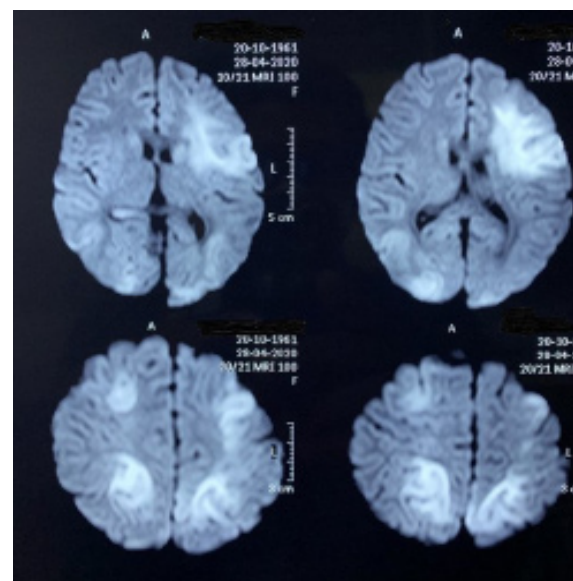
MRI of the brain revealed medium size diffusion restricting lesion in both frontal lobe (Left > Right) and both parieto-occipital lobe.
